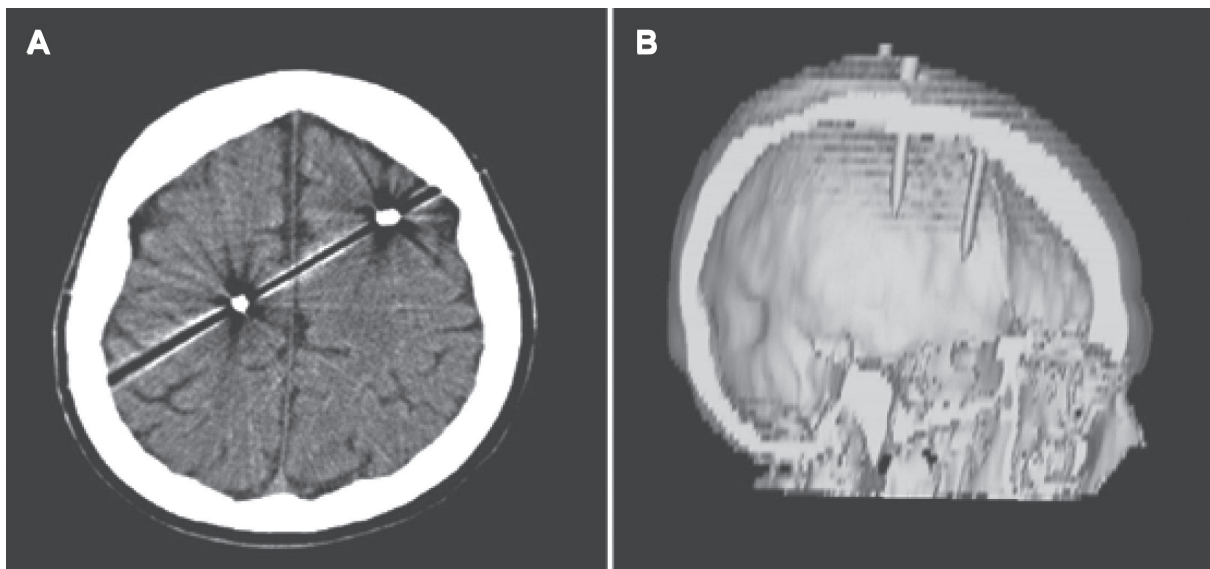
Computed tomography of the brain including (A) axial view, and (B) three-dimensional reconstruction demonstrating no evidence of intracerebral hemorrhage.
